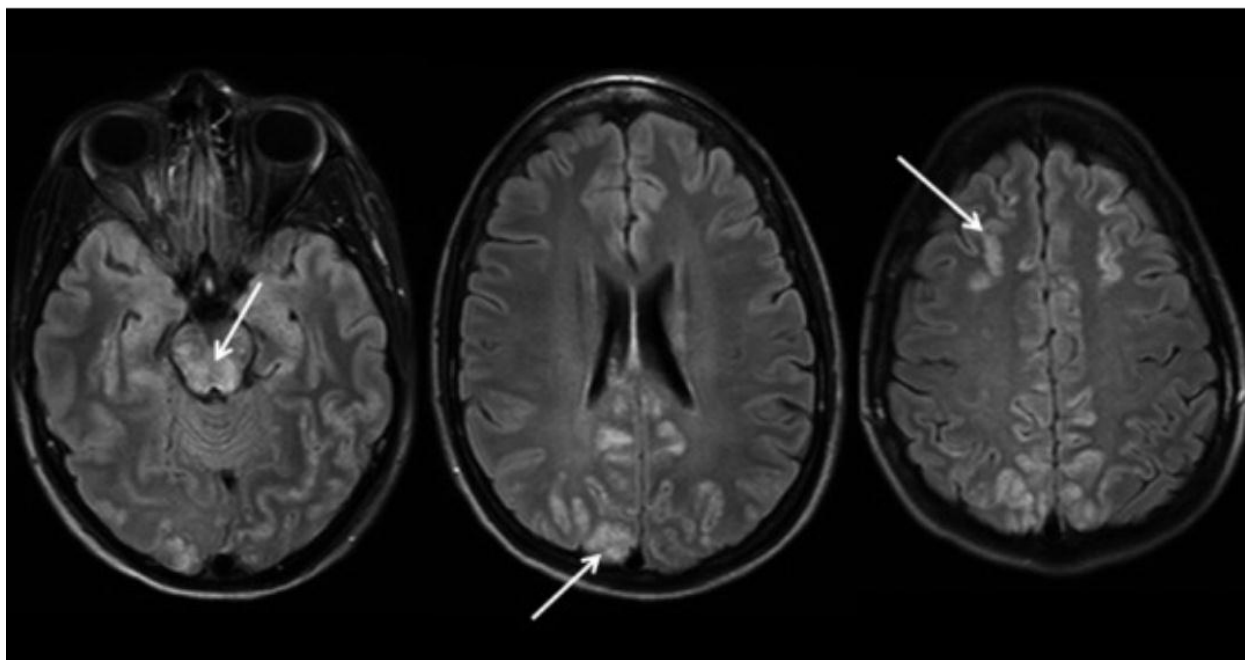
MRI showing hyperintense lesions and FLAIR sequences.
